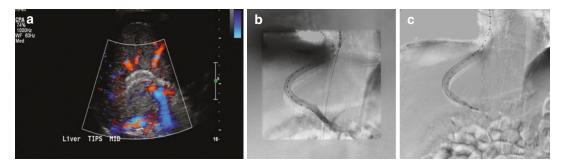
(a) Color Doppler ultrasound of the TIPS postoperative day 1 without evidence of intrinsic flow within the TIPS. (b) Pigtail venography shows contrast refluxing into the portal vein as a result of complete thrombosis. (c)
